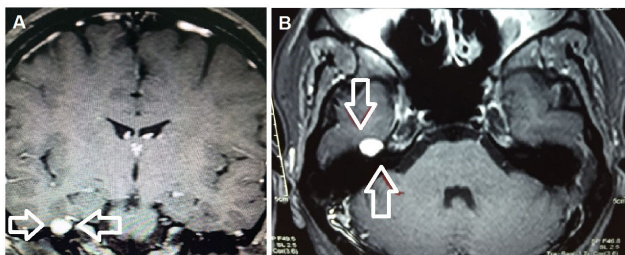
Geniculate ganglion tumor of the right facial nerve. A) Coronal (left) and B) Axial (right) Brain MRI T1 post contrast showing a paramagnetic agent enhancement lesion, measuring 1.1 x 0.9 x 0.9 cm, located on the topography of the geniculate ganglion of the right facial nerve (arrow).
